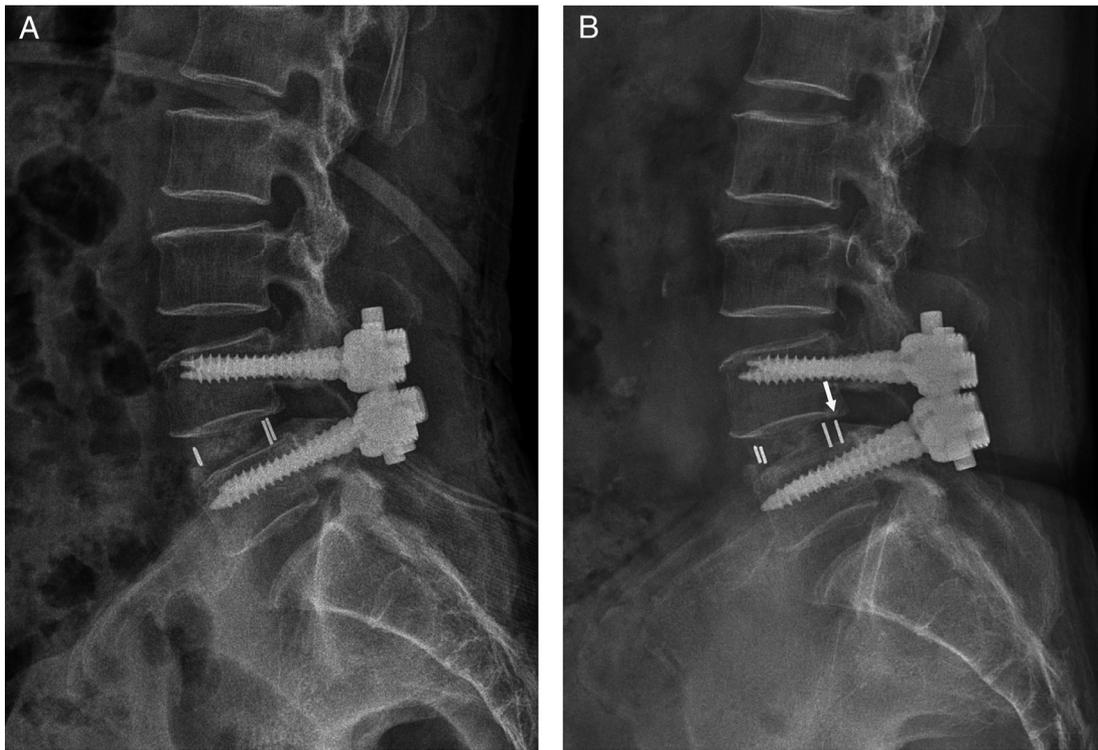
A case showing cage migration without subsidence following TLIF. (A) Immediate postoperative radiograph showing the size and location of both cages is appropriate. (B) Three months after surgery, the cage migrated without subsidence.
